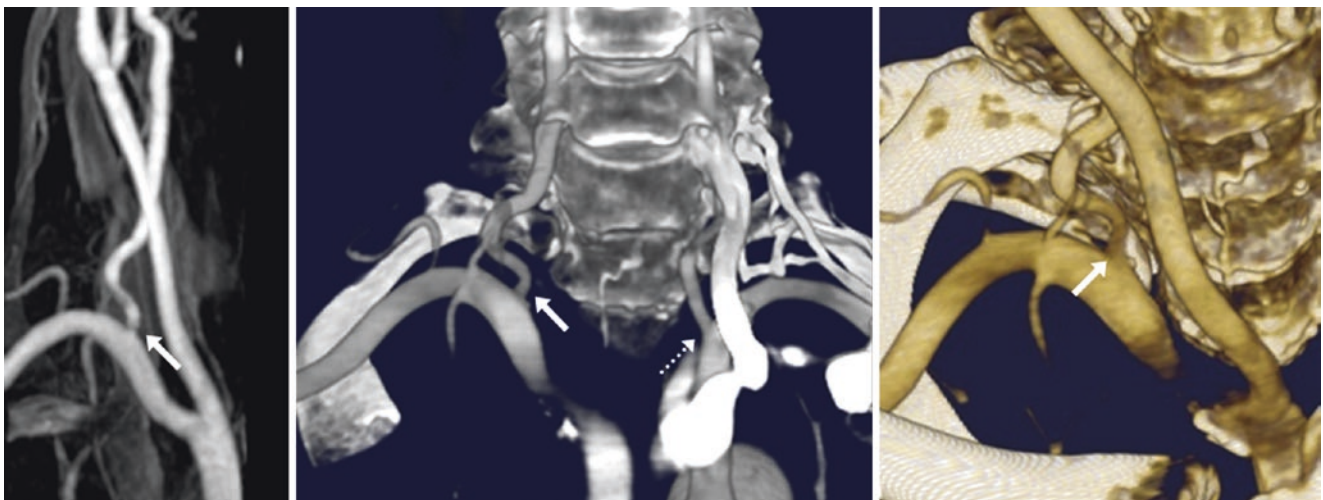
Pseudo-stenosis 72-year-old with a right VA origin stenosis (arrows) suspected on a CEMRA AP view (left), but not present on a CTA with a 24 mm coronal MPR (middle) and a 3D VR AP view (right). The left VA (dotted arrow) was normal
